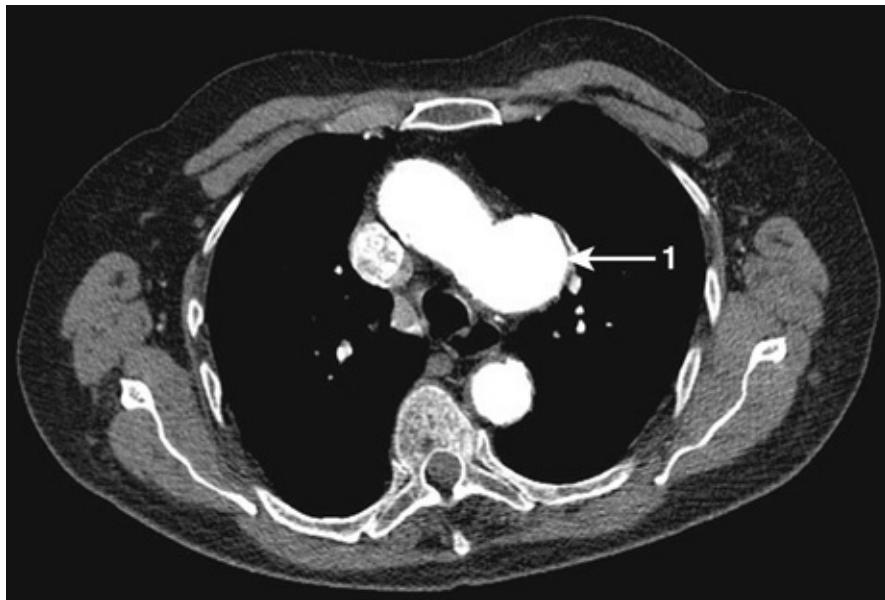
CT of a thoracic aortic aneurysm of a patient being investigated following an abnormal CXR. This slice has been taken at the level of the arch of the aorta. Notice how the arch has lost its normal oblong appearance and has a sac-like enlargement (1). This is an aneurysm of the arch of the aorta. All the contrast is contained in one lumen, suggesting there has been no dissection.
